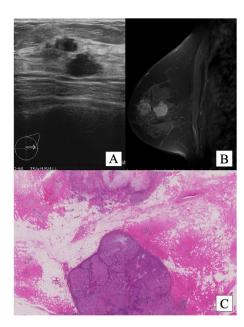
(A) The two separate hypo-echoic masses with irregular surfaces as revealed by ultrasonography. (B) MRI with contrast medium revealed an internally heterogeneous tumor and an internally homogenous tumor. (C) There were two separate nodules. The size of one nodule was 12x11 mm (lower tumor), and the size of the other was 17x15 mm (upper tumor). Magnification: x0.9.
